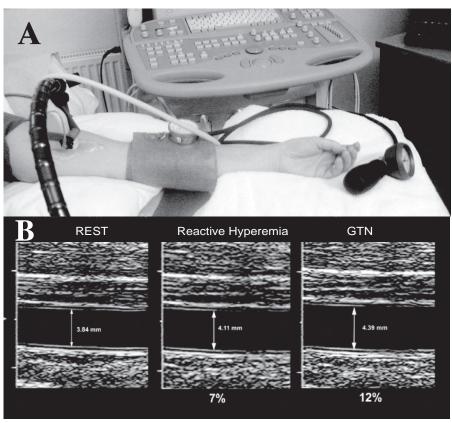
Measurement of flow-mediated vasodilatation using the non-invasive ultrasound technology.
